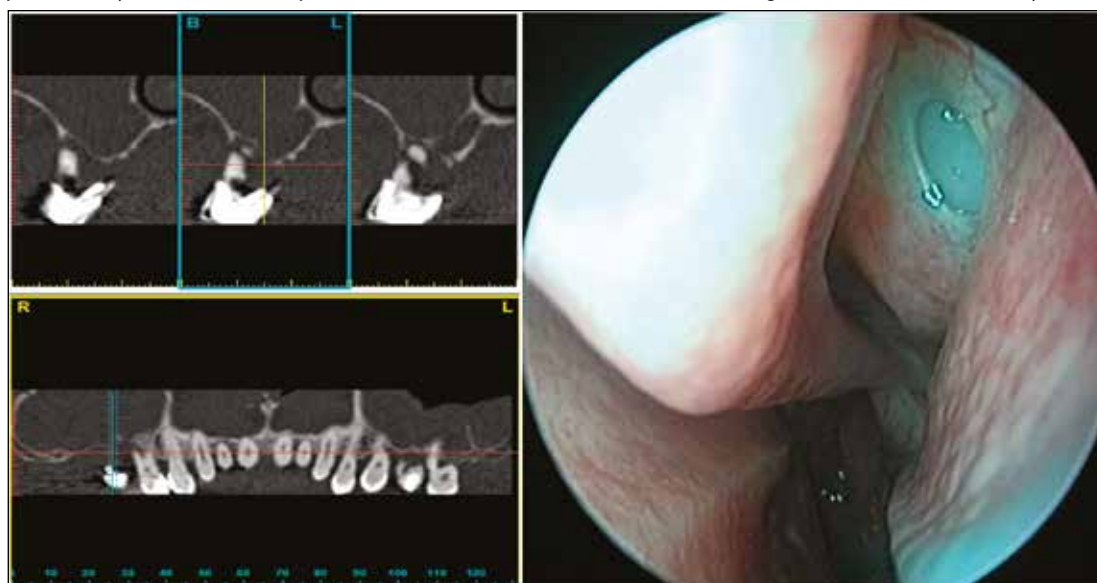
Fragment of computed tomography of the upper jaw of the 59-year-old male patient G., case record No.89. Bilateral total thickening of mucous membrane, obstruction of the ostiomeatal complex. On the right: demonstration of the blocked insolation of the maxillary sinus.
